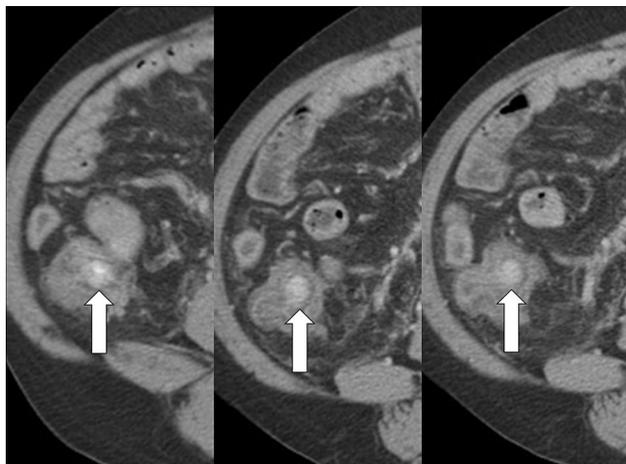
A 55-year-old man with liver cirrhosis. Multiphasic enhanced CT images show a small, polypoid intraluminal mass, which shows enhancement through three phases (the arterial, portal venous, and equilibrium phases), in the terminal ileum. This mass was found incidentally during liver CT examination and was confirmed to be capillary hemangioma in the terminal ileum after colonoscopic removal
